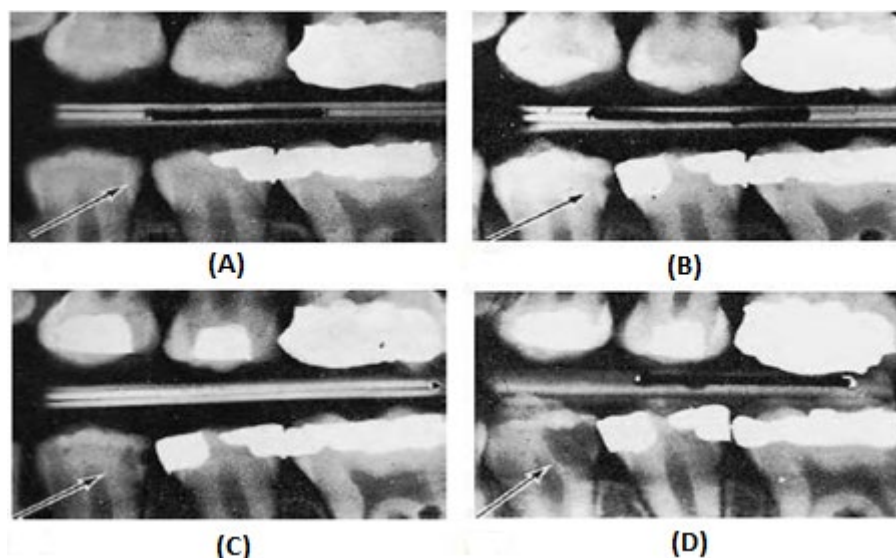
Radiographs recording the progress of a proximal decay on the distal part of a patient's. (A) Initial enamel decay (B) after 9 months (C) after a year, extended decay (D) 2 year later large black area of decay (6).
